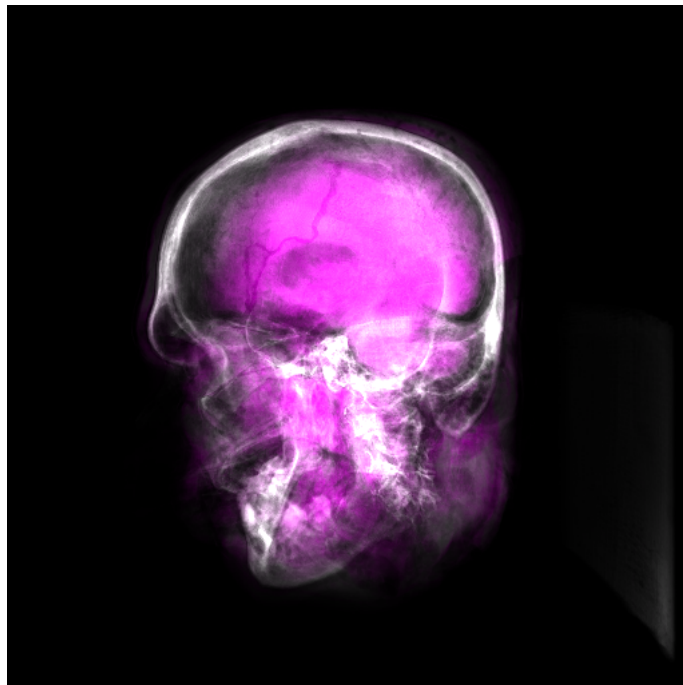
Volume rendering of a CT volume of a human skull with regions corresponding to soft-tissue highlighted in purple using a transfer function.
